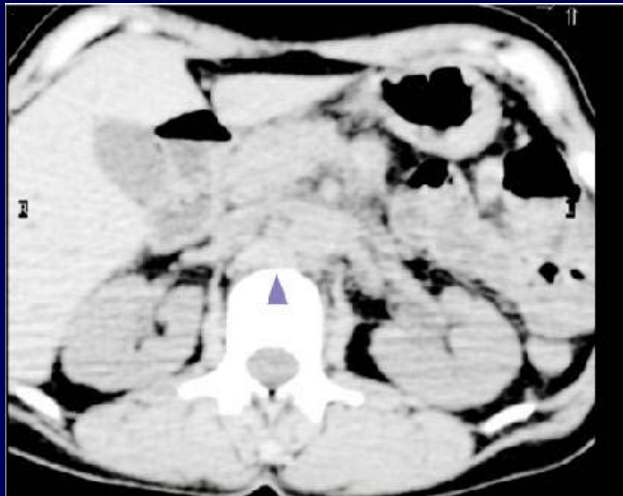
CT scan through the abdomen. Arrowhead points to a residual mass in the abdomen following chemotherapy. It was uncertain or not whether this was active lymphoma
